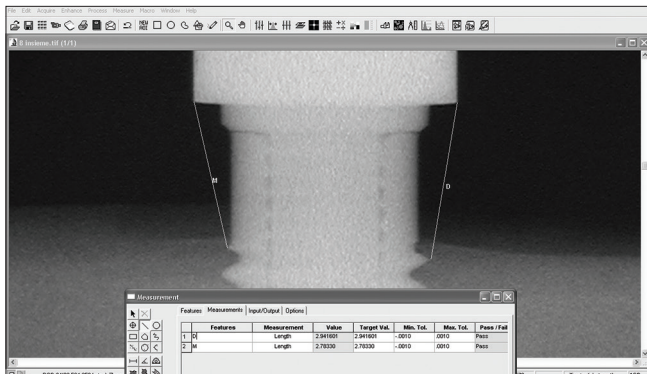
Measure of possible micro-movements on every radiographic image by means a specific software
